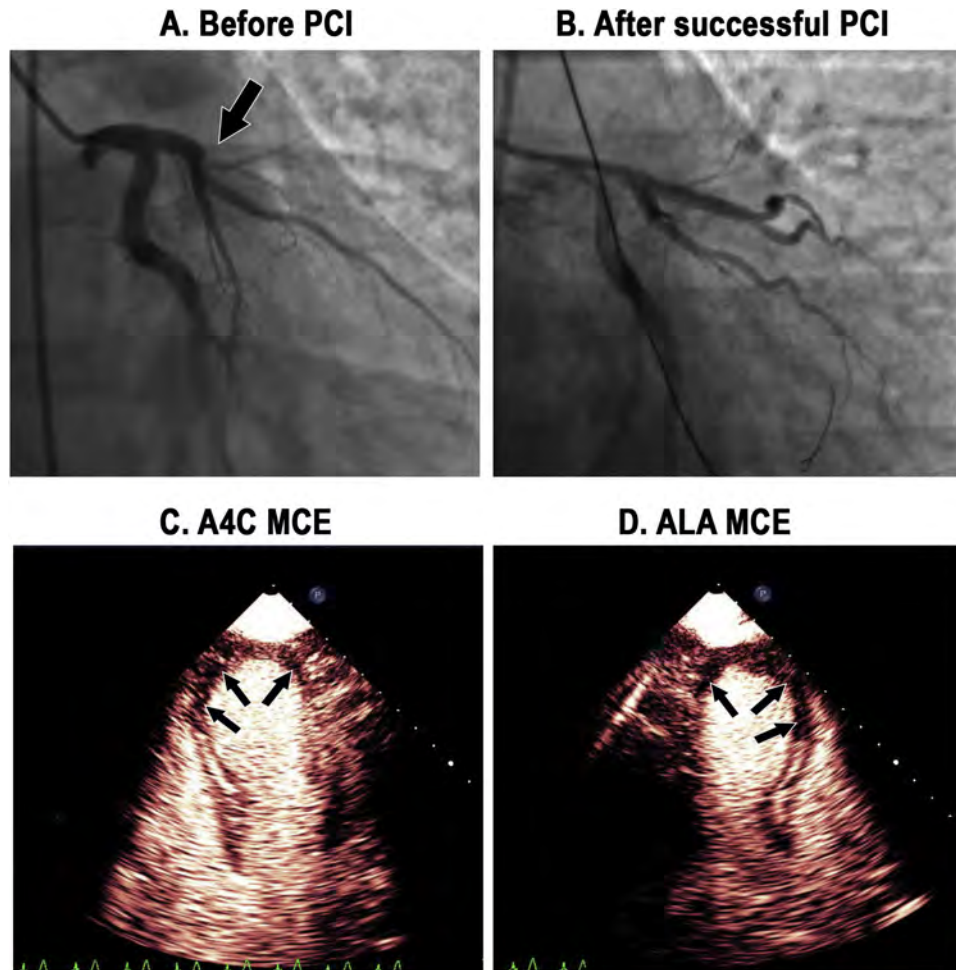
An example of persistent microvascular obstruction after angiographically successful percutaneous coronary angioplasty (PCI) of the left anterior descending coronary artery (LAD) (A,B). During the UEA infusion 24 hours after the successful PCI, there was still a large microvascular defect in the LAD territory noted in the apical four-chamber (A4C) (C) and long-axis (ALA) (D) windows (arrows).
